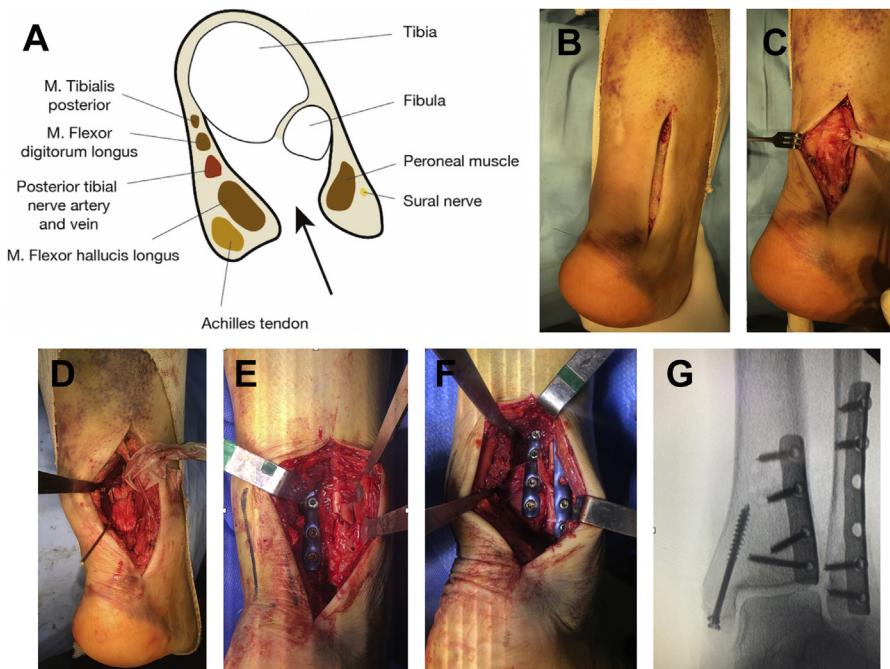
Posteriorlateral approach: anatomic considerations. (A) A skin incision is made between the posterior edge of the lateral malleolus and the lateral aspect of the Achilles tendon. (B) Identify the peroneal tendons fascia and sural nerve. (C) Dissection is performed: the flexor hallucis longus medially, Peroneal tendons, and sural nerve laterally. Temporary fixation of the posterolateral fragment. (D) The posterolateral malleolar fragment is fixed using screws and buttress plate. (E) The posterolateral malleolar fragment and fibula are fixed. (F) Postoperative radiographs after open reduction and internal fixation of the posterolateral malleolar fragment and lateral malleolus. In the same patient from a medial approach, we made an open reduction and internal fixation of the medial malleolus with 2 screws (G).
